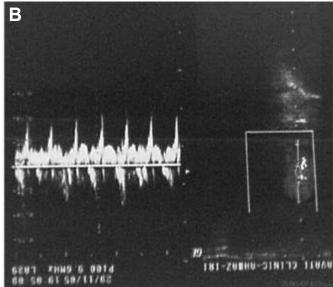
A. Color Doppler ultrasonography reveals the arterial flow.
